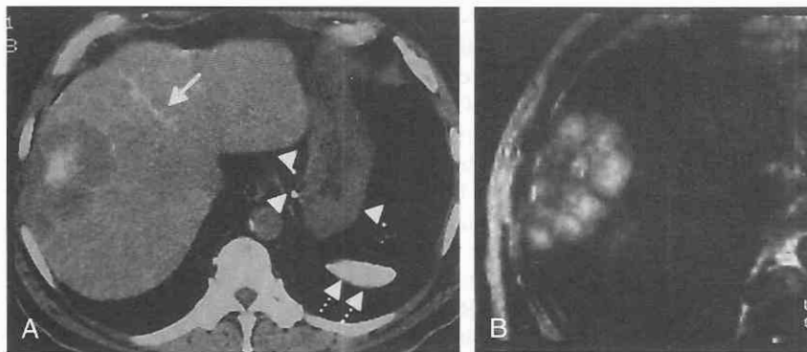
Hemangiosarcoma in a patient with a history of thorium dioxide (Thorotrast) exposition. Unenhanced CT scan (A) shows deposition of Thorotrast throughout the entire reticuloendothelial system, particularly in the spleen (dashed arrows), in the perigastric lymph nodes (arrowheads), and in the liver (arrow). In the right liver lobe, the hemangiosarcoma with its cystic appearance and hypodense central sections is seen. The cystic character of the tumor is even more clearly visualized on the T2-weighted MR image (B). (Courtesy of J. Görich, Ulm.)
